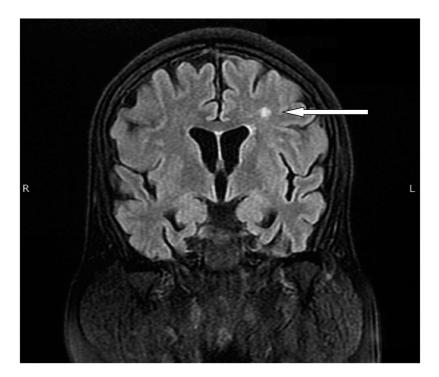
Magnetic resonance imaging of brain (T2) showing abnormal signal intensities.
